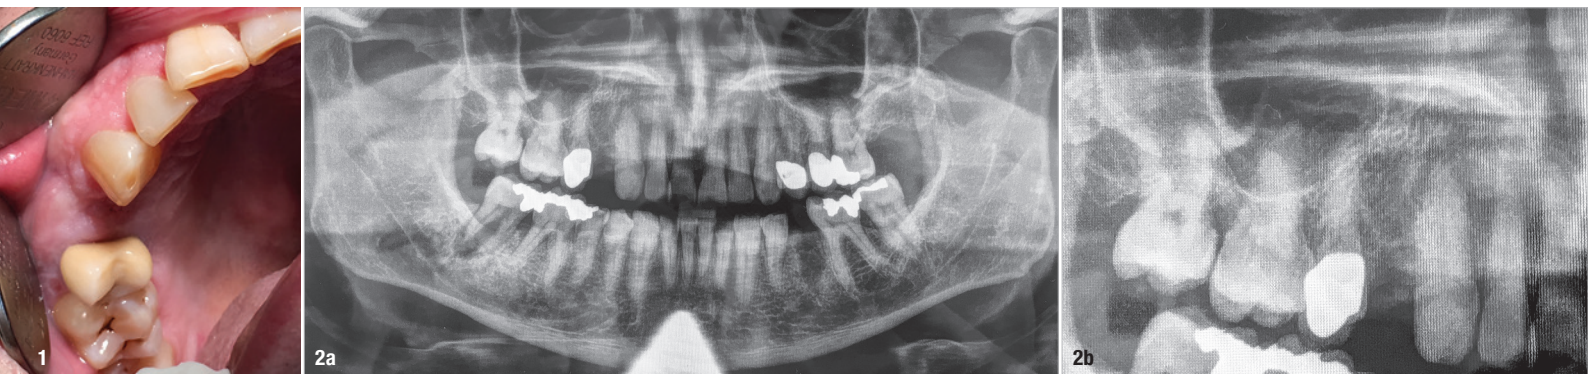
The reduced size of position #14. Figs. 2a & b: Dental panoramic tomogram (a) and periapical radiograph (b) prior to implant placement.
